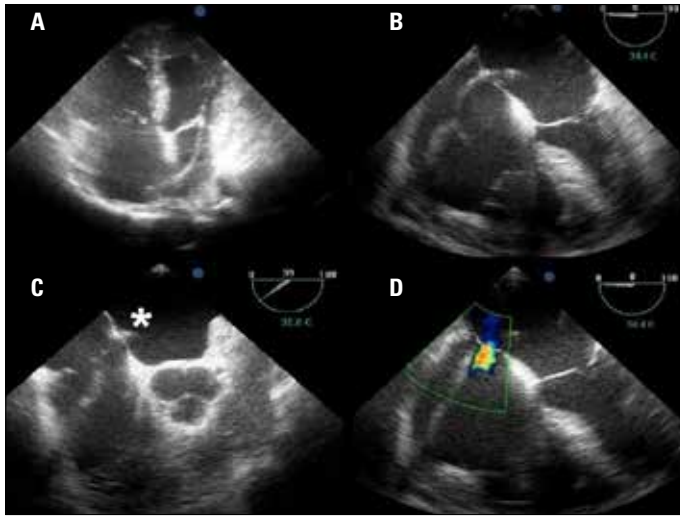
(A) The route of ventricular electrode from the right atrium to the left ventricle on TTE; (B) Ventricular lead passes ASD and reaches to the left atrium on TEE, four chamber view; (C) Ventricular electrode passes ASD (asterisk) on TEE, short-axis view of the aortic valve; (D) Transition from ASD by color Doppler and the position of the electrode
